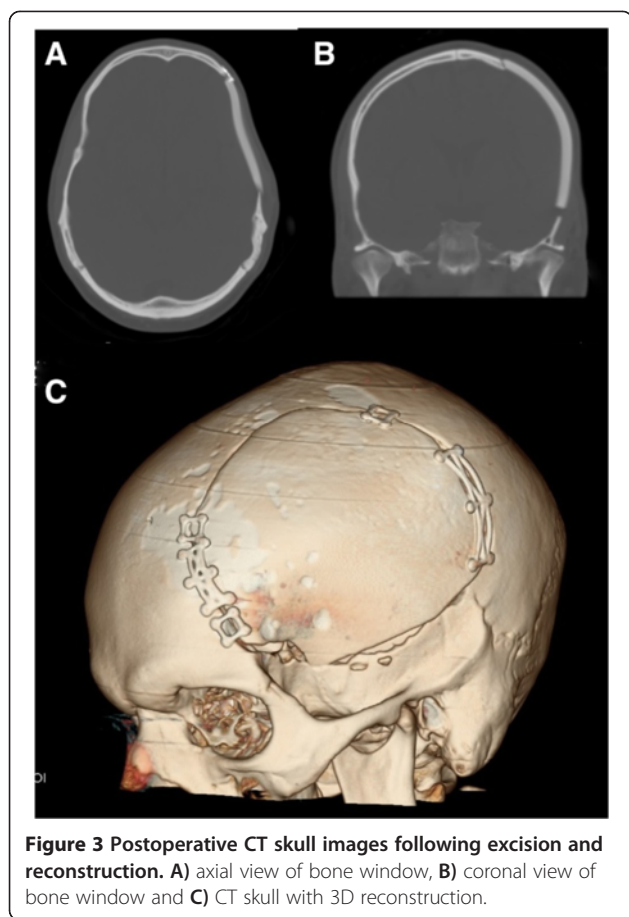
Postoperative CT skull images following excision and reconstruction. A) axial view of bone window, B) coronal view of bone window and C) CT skull with 3D reconstruction.
